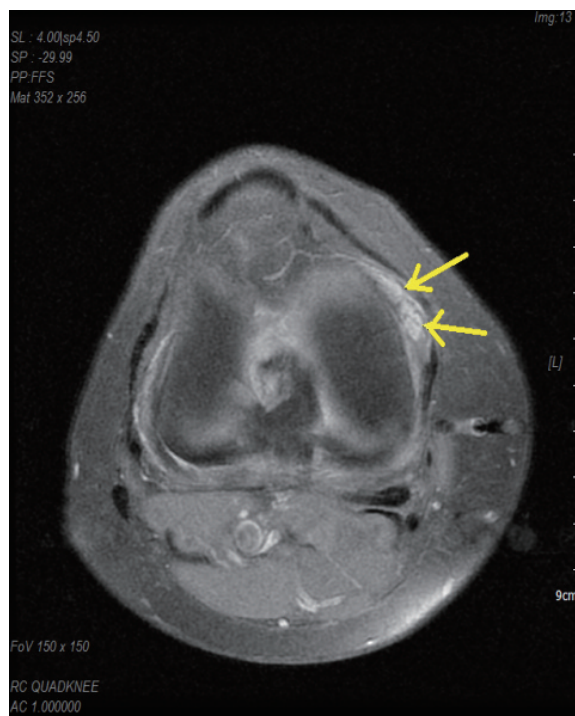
Right knee MRI of case 2 (12/26/2016)
